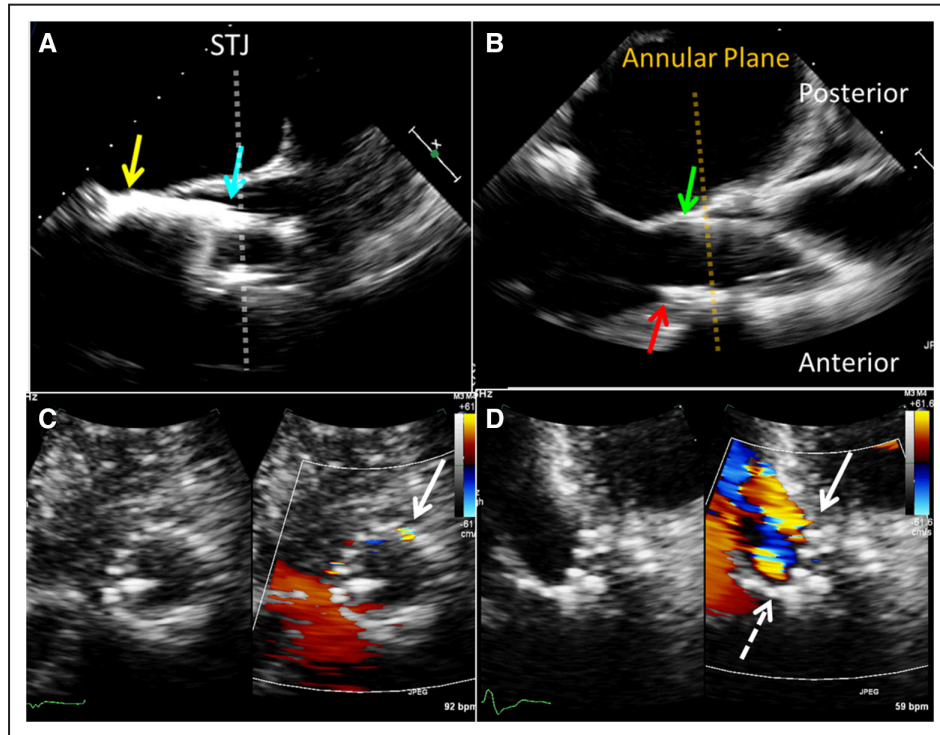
Transesophageal and transthoracic imaging during transcatheter aortic valve replacement. A, Positioning of a crimped balloon-expandable valve (aortic end at blue arrow and ventricular end at yellow arrow). B, The positioning of a self-expanding valve (posterior edge at green arrow and anterior edge at red arrow). Intraoperative transthoracic imaging for paravalvular regurgitation should be performed from multiple imaging planes. C, Parasternal short-axis views suggest a single small regurgitant jet at 2 o'clock (white arrow); however, (D) from an apical 3-chamber view shows a second jet (white dashed arrow).
